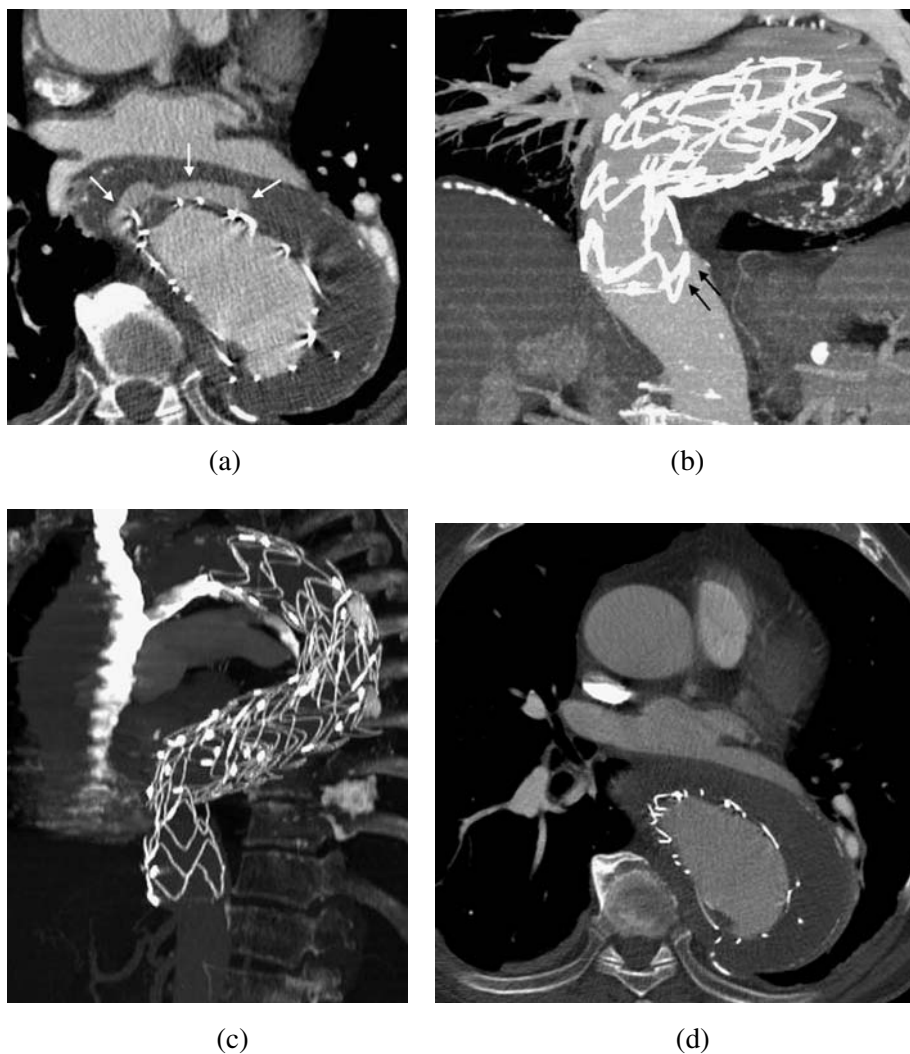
CT is very helpful in the follow-up of aortic dissections treated by endovascular techniques. In this example, an endoleak can be visualized after the deployment of a stent graft in the descending aorta, represented by contrast enhancement within the thrombosed sac and outside the graft lumen ((a), axial scan, arrows). The endoleak is caused by the incomplete anchorage of the stent graft at the level of the distal neck ((b), MIP reconstruction on coronal plane, arrows). Therefore, an extended cuff is positioned percutaneously at the distal level. CT control performed after 1 month shows the adequate fixation of the stent graft and of the cuff to the aortic wall ((c), MIP reconstruction on sagittal plane); the endoleak is no longer visualized ((d), axial scan).
